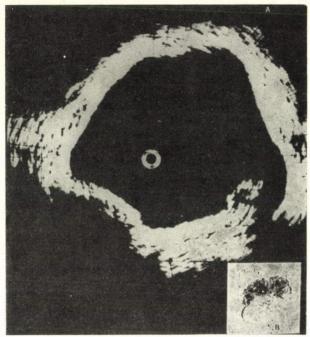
$U_3$ : Intravesical ultrasonograms of a tumour situated on the left lateral wall. The wall is irregular, its part under the tumour cannot be visualized, and depending on the depth of the infiltration, the continuity is broken. B.  $pT_3$ : The transitional cell carcinoma has infiltrated into the deeper muscle layer, too
